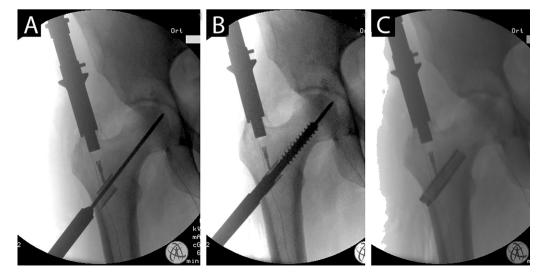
Intraoperative X-ray intensifier imaging showing the K-wire insertion along the femoral neck (A), the successive reaming (b) and the nail positioned at the right level with the cephalic lag-screw inserted and visible just in the proximal part (C).
